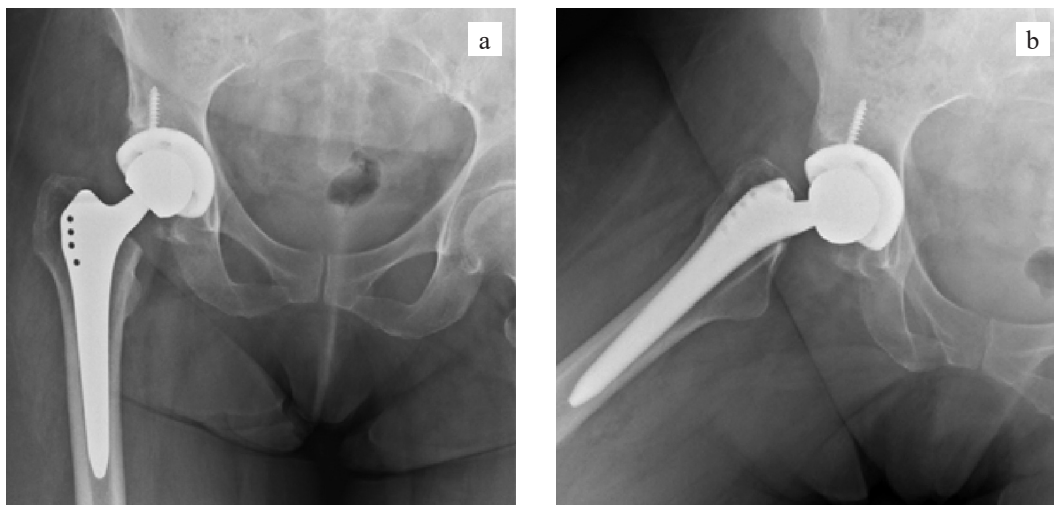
X-ray four years after total hip arthroplasty of the right hip showing a correct and stable position of the endoprosthesis with evidence of osteointegration: a, hip joint in neutral position; b, hip joint in abduction position
